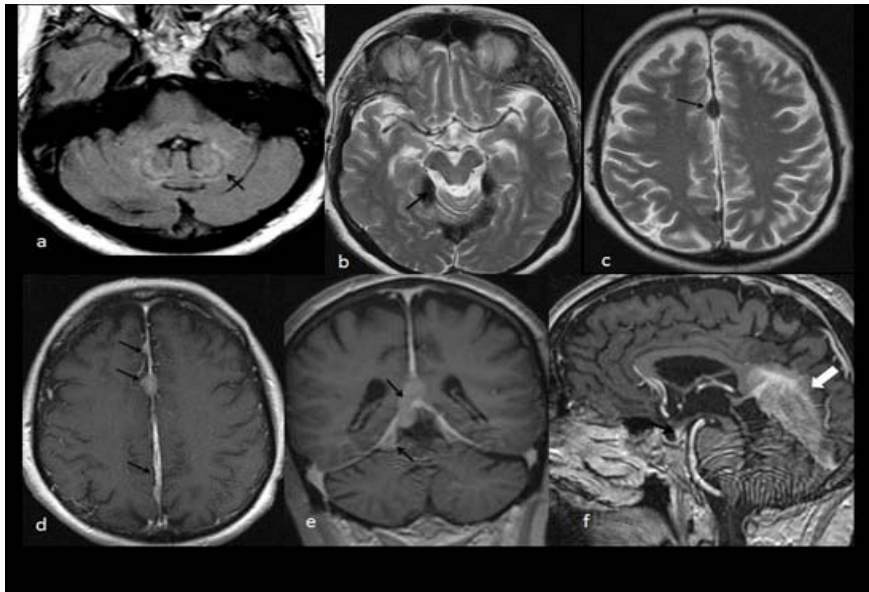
(a) Axial T2-Flair weighted image shows signal abnormality within the bilateral dentate nuclei (arrow); (b) Axial T2 weighted image shows extensive extra-axial lesions with T2 hypointensity (arrow) along the thickened cerebellar tent and (c) in several regions along the dura of the falx. T1-weighted postcontrast image reveals (d) on axial image a focal and homogeneous enhancing epidural lesion that is meningioma-like along the falx cerebri and (e) the cerebellar tent (coronal image); and (f) on sagittal sequence at the sella level, it indicates a thickened enhancing pituitary stalk (black arrow) and thickened irregular enhancement along the straight sinus (white arrow).
